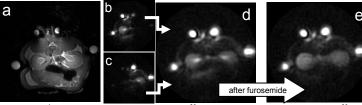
(a) ¹H MR image co-registered with ²³Na bilateral kidney images. (b, c) ²³Na birdcage volume resonator, and single-coil images acquired by phased array coil are depicted as (d) sum-of-squares image. (d,e) ²³Na images before and after furosemide injection are shown.
